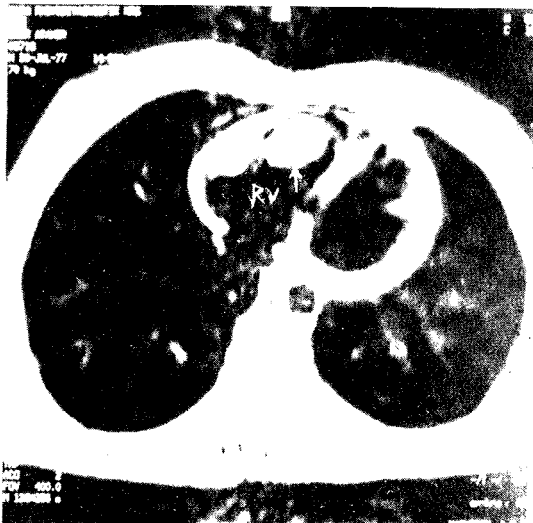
Preoperative magnetic resonance imaging (a; sagittal b; horizontal section) showed the large mass (arrowheads) in the right ventricle and prolapsing through the pulmonary valve. RV: right ventricle.
